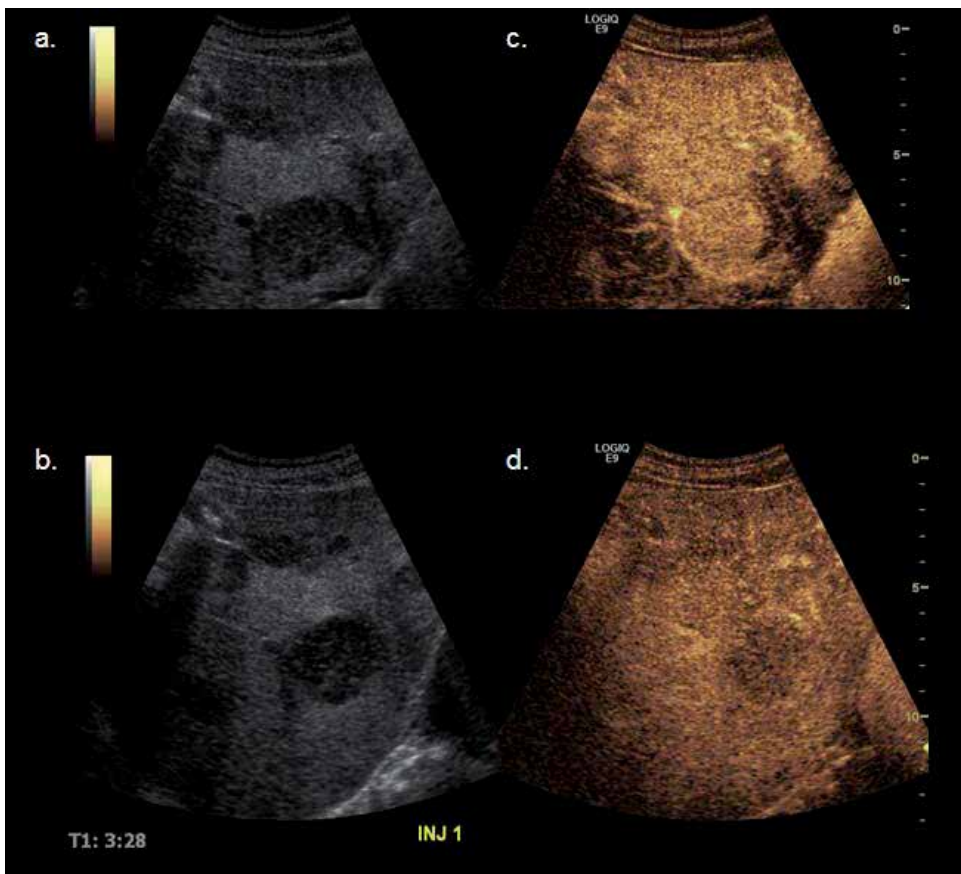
Four images from a patient with pathologic proven rectal neuroendocrine tumor that is metastatic to the right lobe of the liver. (a) & (b) are conventional ultrasound images of the right lobe of the liver which demonstrates a well circumscribed, hypoechoic mass. (c) & (d) are contrast mode rapid ultrasound following injection of $\sim 3 \times 10^{-8}$ microbubbles that are approximately 2.5 microns in size in a volume of 2.4mL. Panels (c) and (d) demonstrate different timepoints which demonstrate enhancement of the tumor fairly homogenously in (c), and in (d) washout of the tumor with enhancement of the hepatic venous system. (Figure from Dhyani & Samir et. al. unpublished data)
